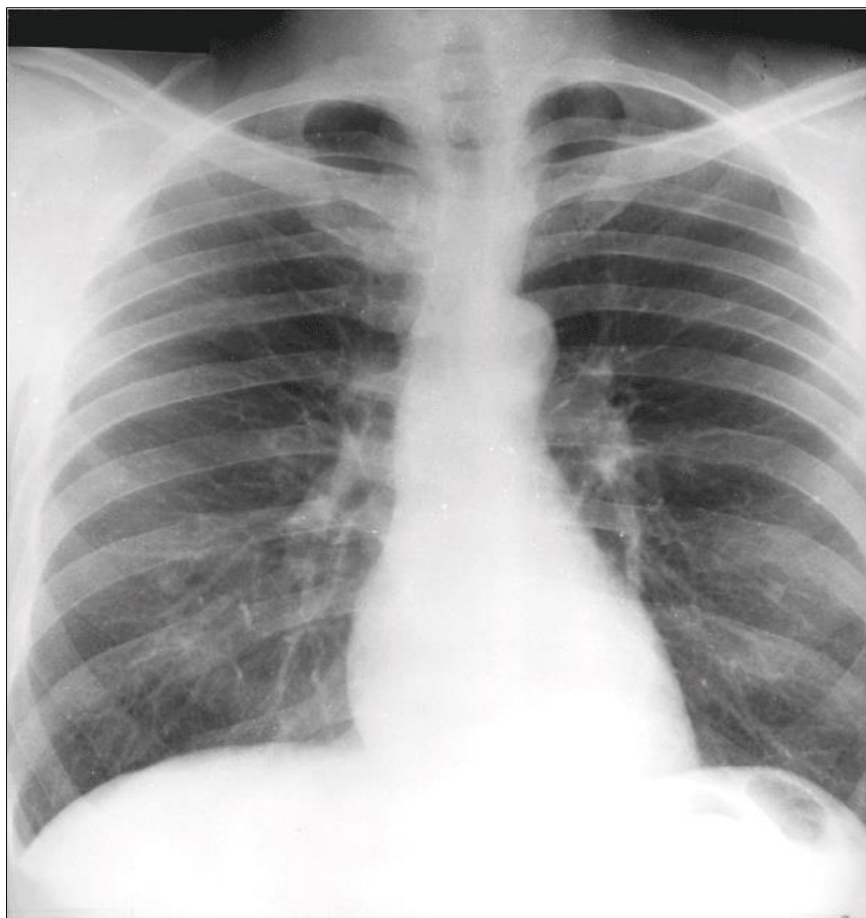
Chest Xray (Posteroanterior view)
